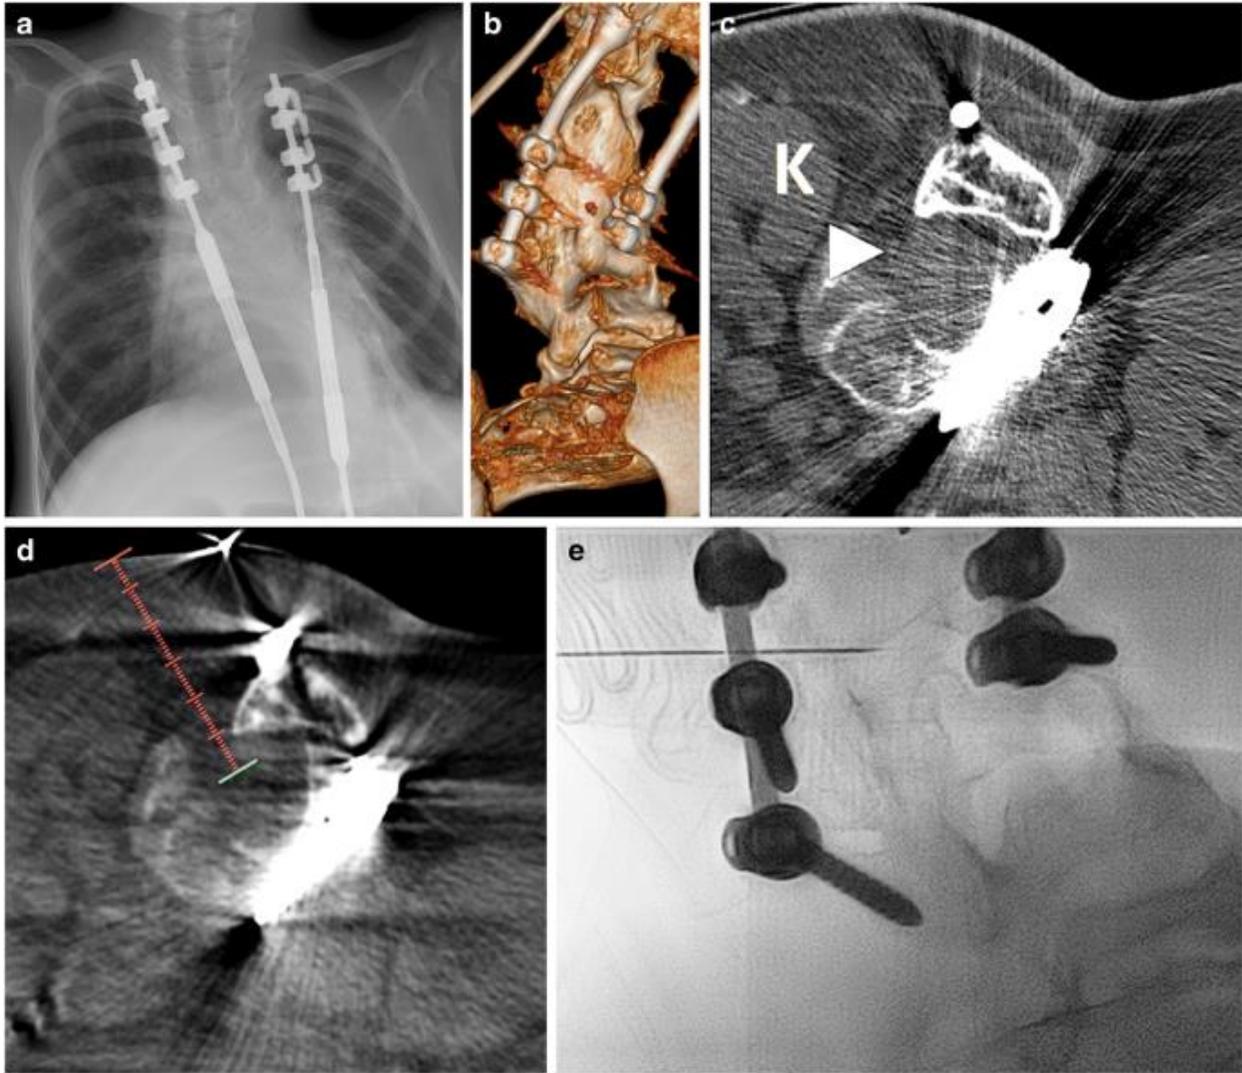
Spinal muscular atrophy type 2 and rod insertion in a 10-year-old boy. a Anteroposterior radiograph demonstrates thoracolumbar scoliosis with spinal rods. b Three-dimensional reconstruction from source non-contrast diagnostic lumbar spine CT images demonstrates diffuse bony fusion of the lumbar posterior elements, prohibiting interspinous access. c Axial image from the non-contrast diagnostic lumbar spine CT demonstrates plausible spinal canal access via a patent left L2-L3 neural foramen (*arrowhead*). Note needle access route immediately medial to the left kidney (*K*). d XperCT axial image at the level of the left L2-L3 neural foramen with superimposed needle planning into the subarachnoid space via XperGuide. e Fluoroscopic overlay using XperGuide confirms midline needle tip position within the thecal sac at L2-L3
